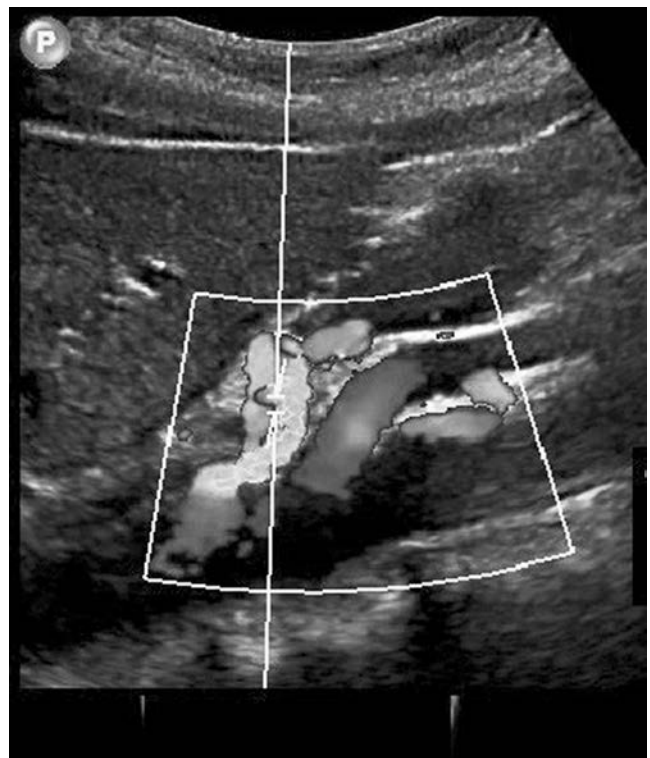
Mesenteric ultrasound of the celiac artery. (Republished with permission of Lainez RA, Richardson WS. *Ochsner J.* 2013;13(4):561–4.²³)
